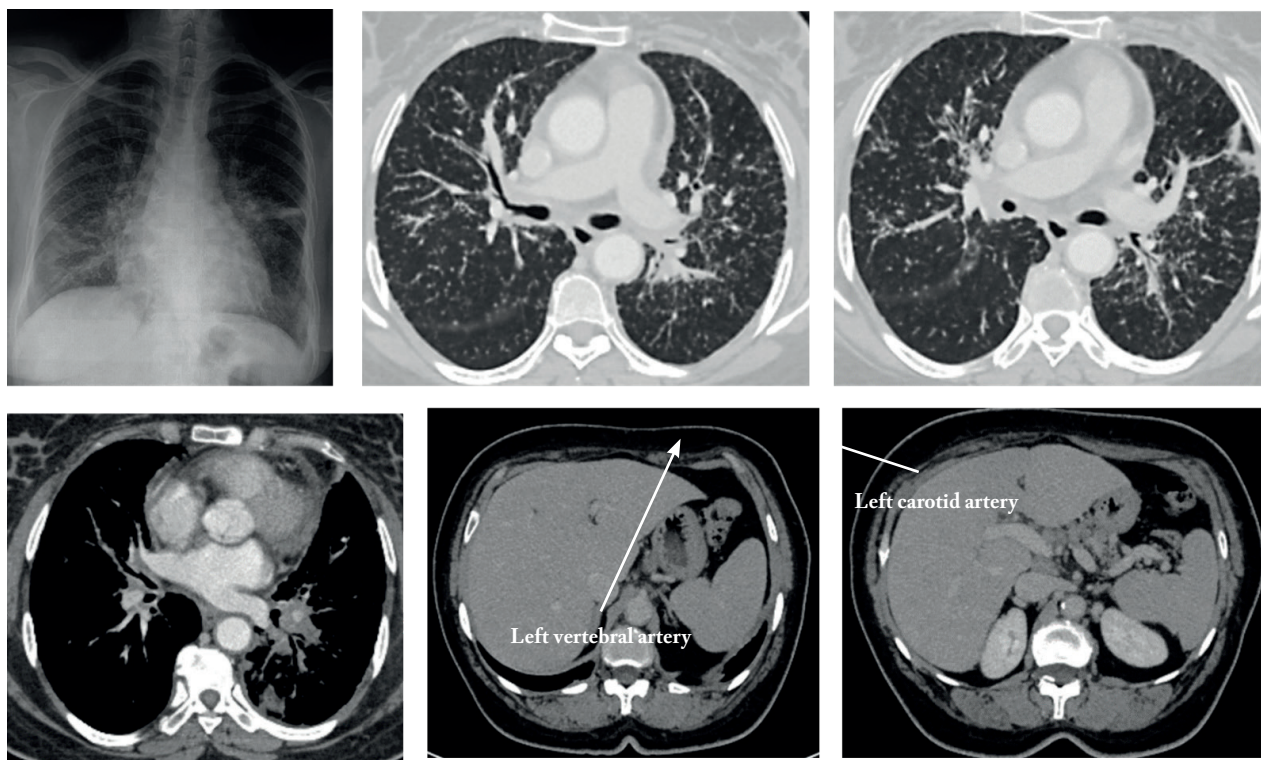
Chest radiography showing bilateral interstitial syndrome predominating in the bases. A computed tomography (CT) scan: micronodules with lymphatic distribution in both lungs with clavicular, mediastinal and abdominal lymph nodes and dysmorphic micronodular liver
